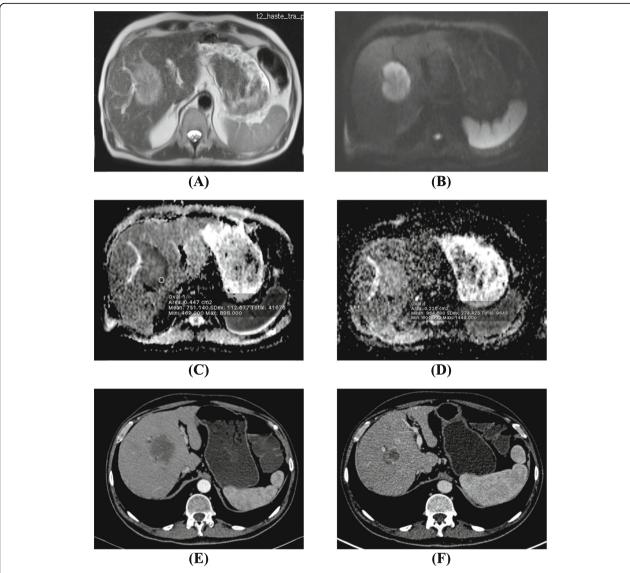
Case (2): A 57 year old male patient with history of rectal adeno-carcinoma with hepatic metastasis. a) Baseline axial T2 MRI revealed mostly hyper intense lesion in segment VIII/V interface. b) Corresponding axial baseline diffusion weighted image of the previous T2 target lesion with b value of (800 m2/sec) shows the lesion displaying hyper intense signal. c) pre therapeutic ADC image which revealed diffusion restriction and ADC value of 0.73 x10-3 m2/sec. (d) post therapeutic (21 days after chemotherapy) ADC map showing increase in the ADC value up to 0.96 x10-3 m2/sec (e) base line pre chemotherapy CT portal phase; hypo dense lesion with relative peripheral enhancement was noted measuring about 5.6 cm. (f) 2 month follow up CT portal phase revealed significant reduction of the lesion currently seen measuring about 2.3cm (partial response according to RECIST criteria)
